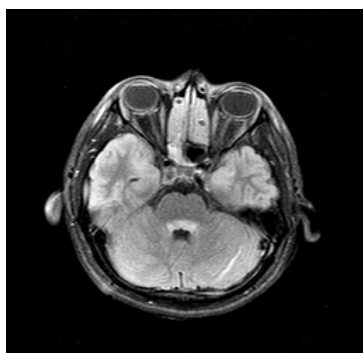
Axial FLAIR MRI series show hyperintensity in dorsal pons
